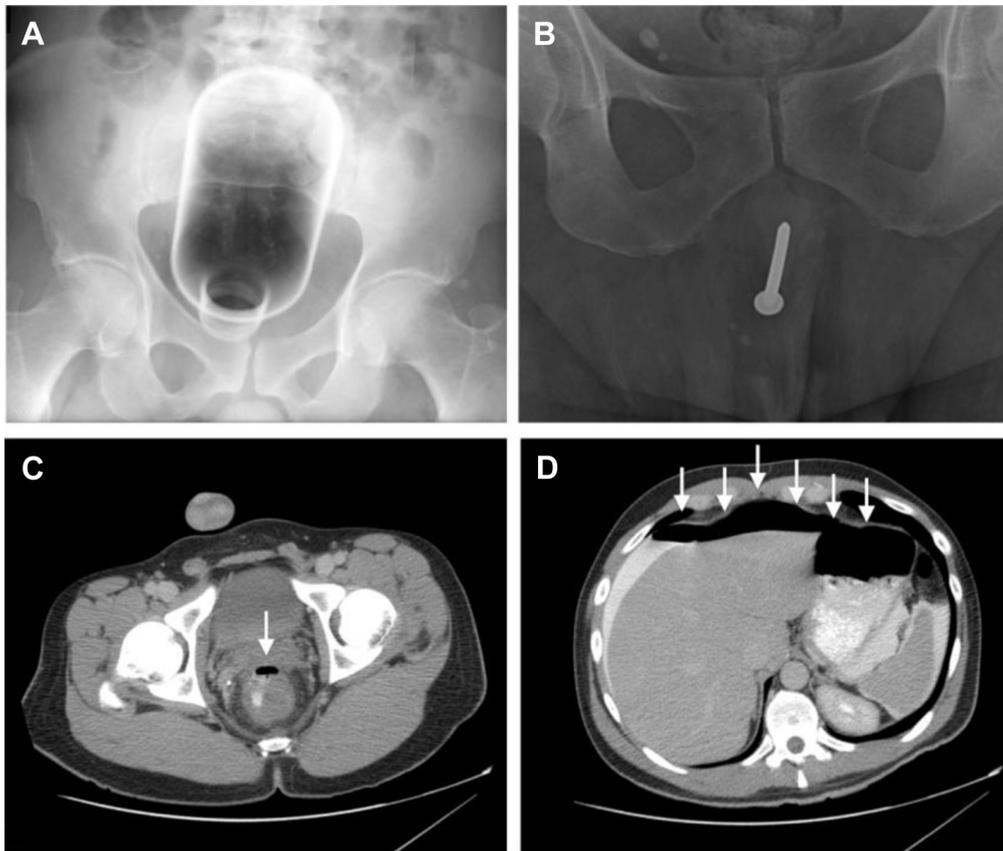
A, Rectally inserted glass bottle. B, A nail inserted into the urethra. C, Axial contrast-enhanced CT status after sharp rectal FB removal causing rectal perforation (white solid arrow). D, Large-volume pneumoperitoneum (white solid arrows), with additional leakage of oral contrast, which is layering in the peritoneal cavity and surrounding the spleen and liver.
